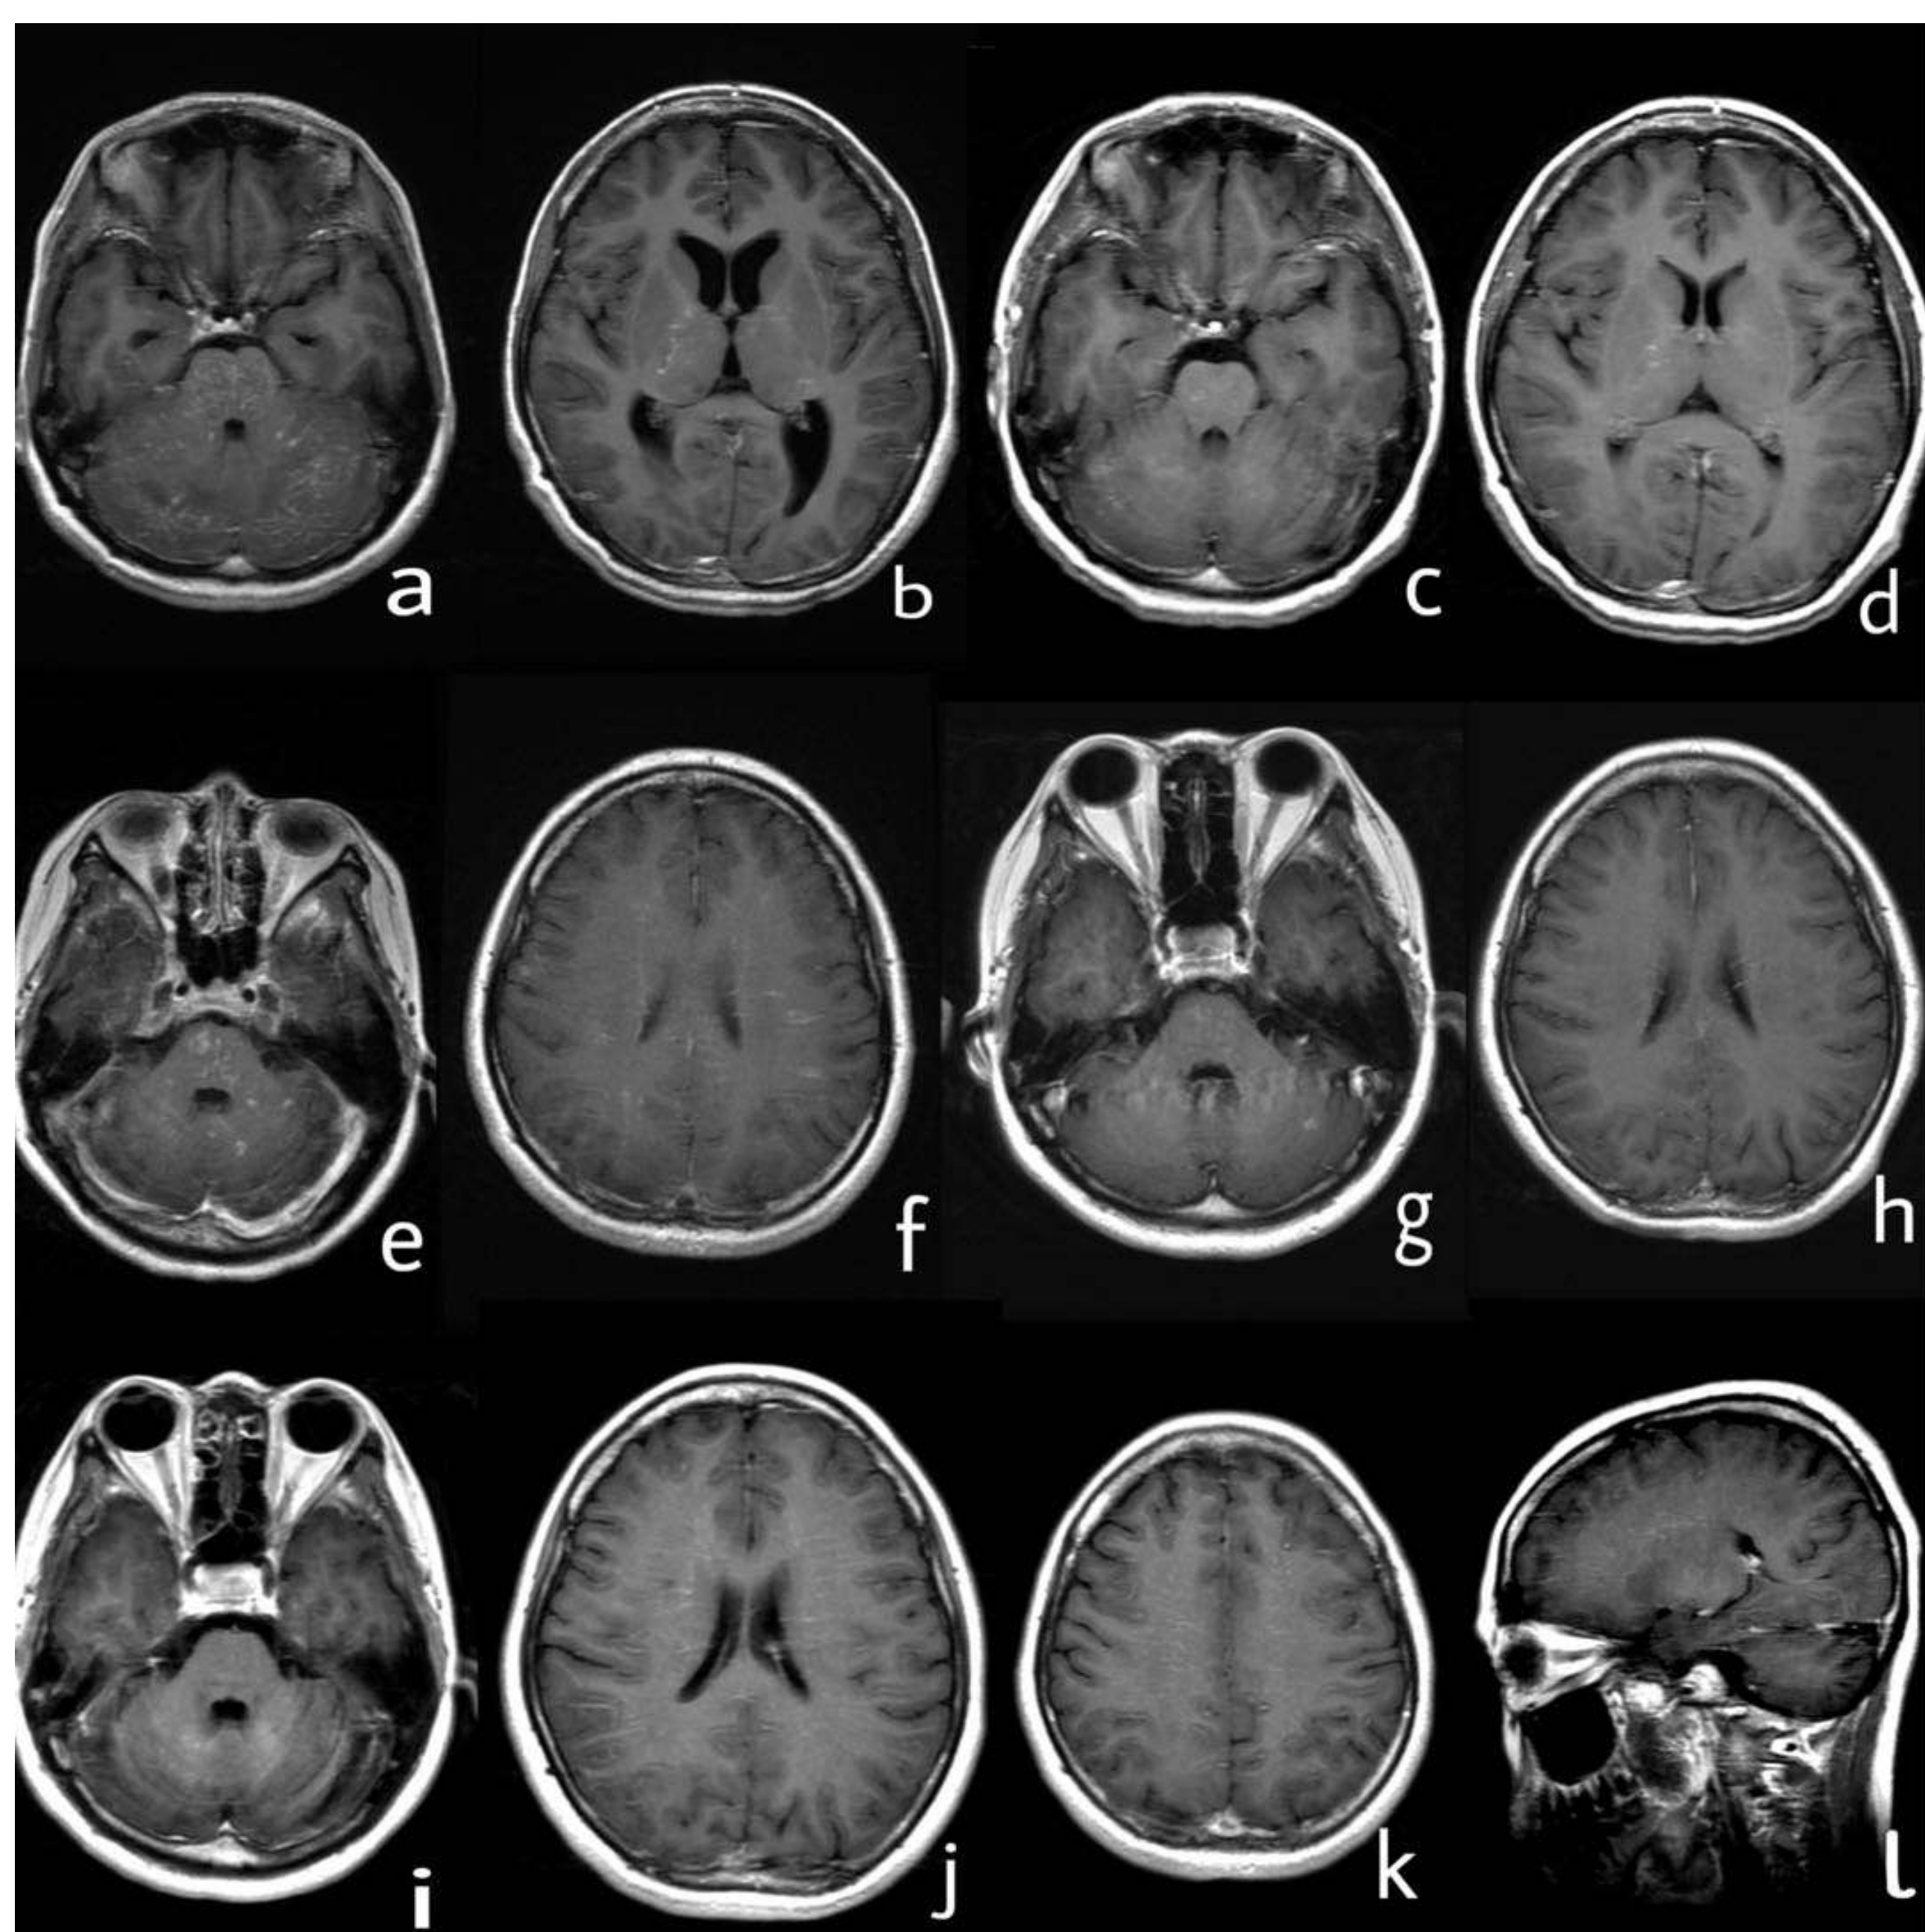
Series of brain MRI with contrast. (a-b) March 2012, curvilinear and punctate enhancement of pontine, cerebellum and basal ganglion was demonstrated. (c-d) June 2012, enhancement of pontine, cerebellum and basal ganglion improved after treatment with steroids. (e-f) June 2015, novel dot-like and liner enhancement in pontine, semiovale center and juxtacortical area was showed. (g-h) September 2015, enhancement in pontine, semiovale center and juxtacortical area improved again after treatment with steroids. (i-l) September 2019, novel dot-like and liner enhancement in both hemisphere of the cerebellum, semiovale center, basal ganglion, thalamus was demonstrated.
